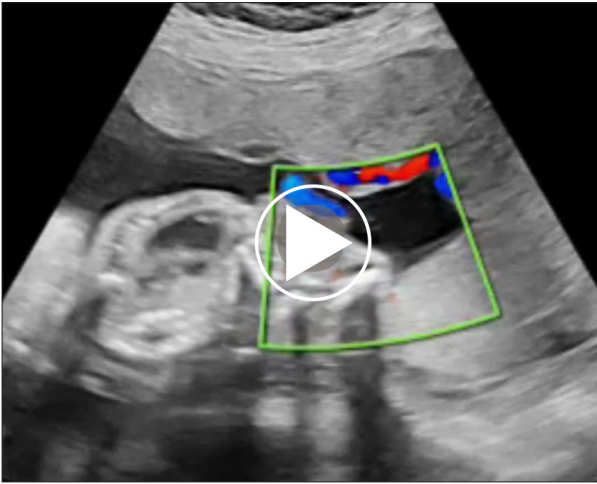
Fetomaternal ultrasound result revealing body stalk anomaly: (A, B) very short umbilical cord (UC); (C) severe abdominal wall and limb defect; and (D) severe limb defect.
